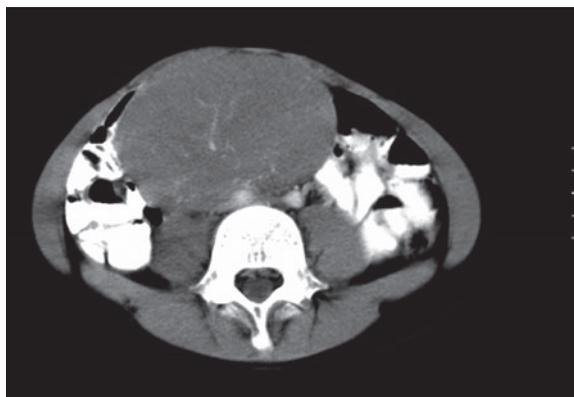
Girl WE. Abdominal CT study after contrast medium administration – a solid tumor of the hypogastrium with „network” enhancement.
